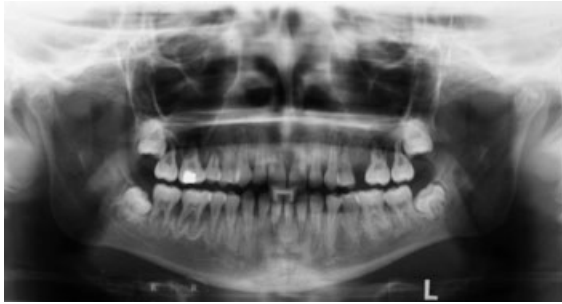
Panoramic radiograph taken at initial submission of the patient showing generalized root resorptions and bone sclerosis adjacent to the resorbed roots particularly evident in the mandibular premolar and molar areas.
